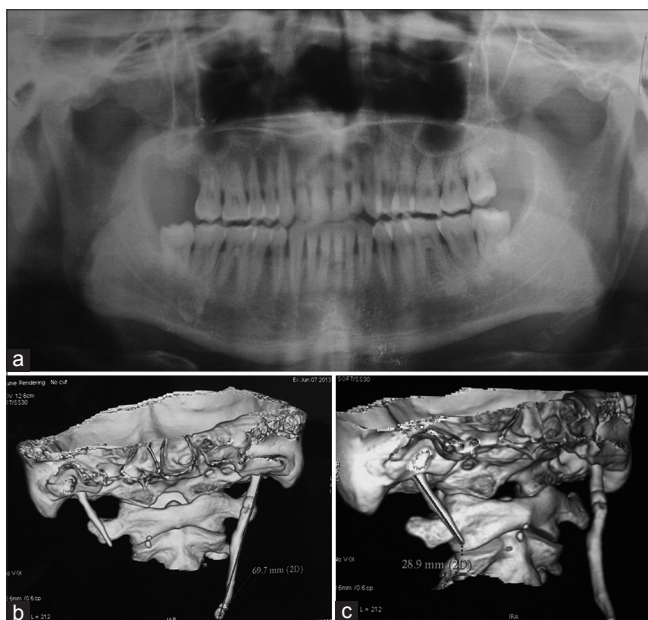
(a) Orthopantomogram shows elongated left styloid process. (b) Computed tomography shows left elongated styloid process of size 69.7 mm. (c) Computed tomography shows right elongated styloid process of size 28.9 mm
